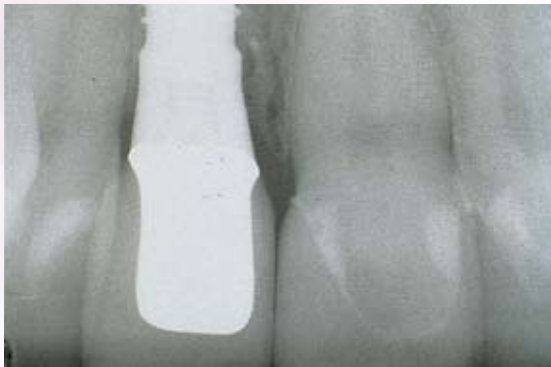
Final radiograph implant in the #8 position. The implant diameter (4.3 mm) allows for adequate interproximal crest width.
